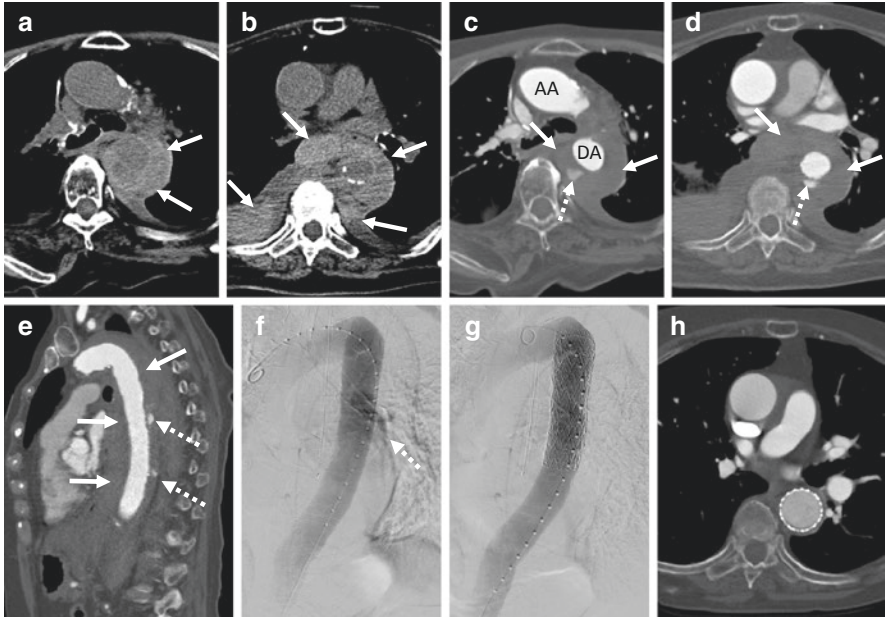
Axial (a-d) and sagittal (e) postcontrast CT images demonstrate a ruptured type B IMH in an 80-year old woman with acute chest and back pain. High density material consistent with acute hemorrhage (arrows) is seen around the descending aorta (DA), throughout the posterior mediastinum, and in the pleural spaces bilaterally, right more than left. Intramural blood pools (IBPs) are present (dotted arrows). Angiographic views pre- (f) and post- (g) endovascular stent placement show successful coverage of IBPs and resolution of contrast extravasation. Single axial postcontrast CT image 18 months later (h) reveals resolution of IMH and hemorrhage. AA Ascending aorta
